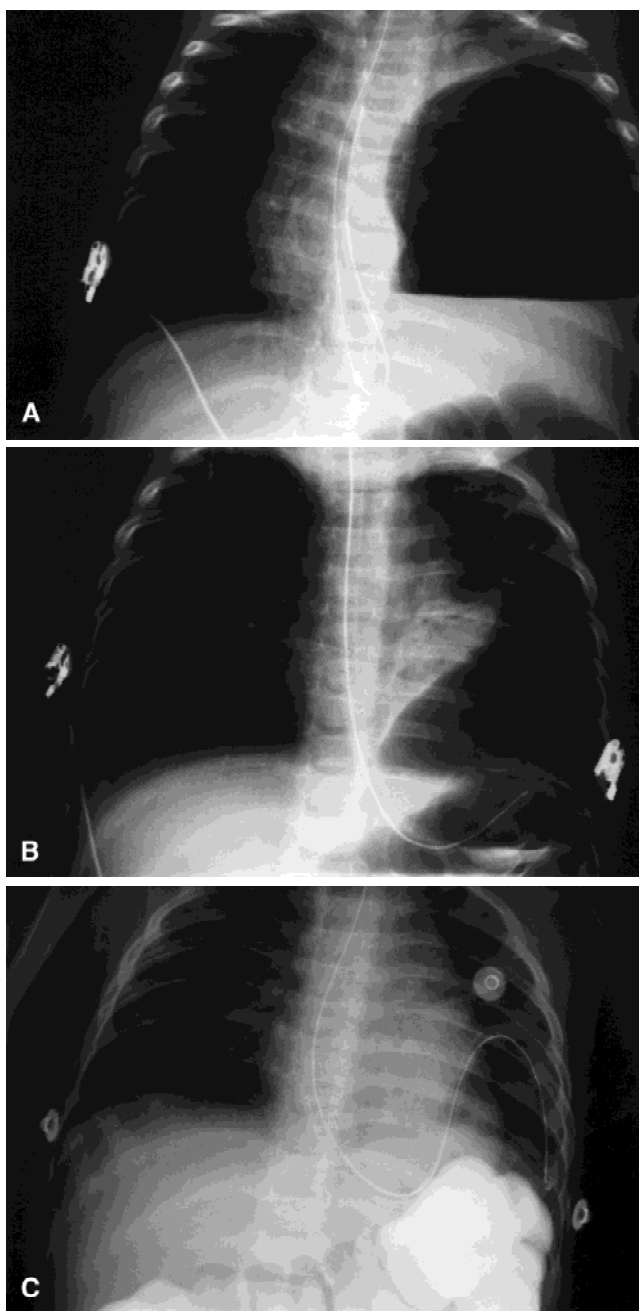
A–C Case 1. Chest radiograph demonstrating acute gastric dilation after incarceration associated with a rightward mediastinal shift. The nasogastric tube is coiled in the esophagus and thus ineffective.
